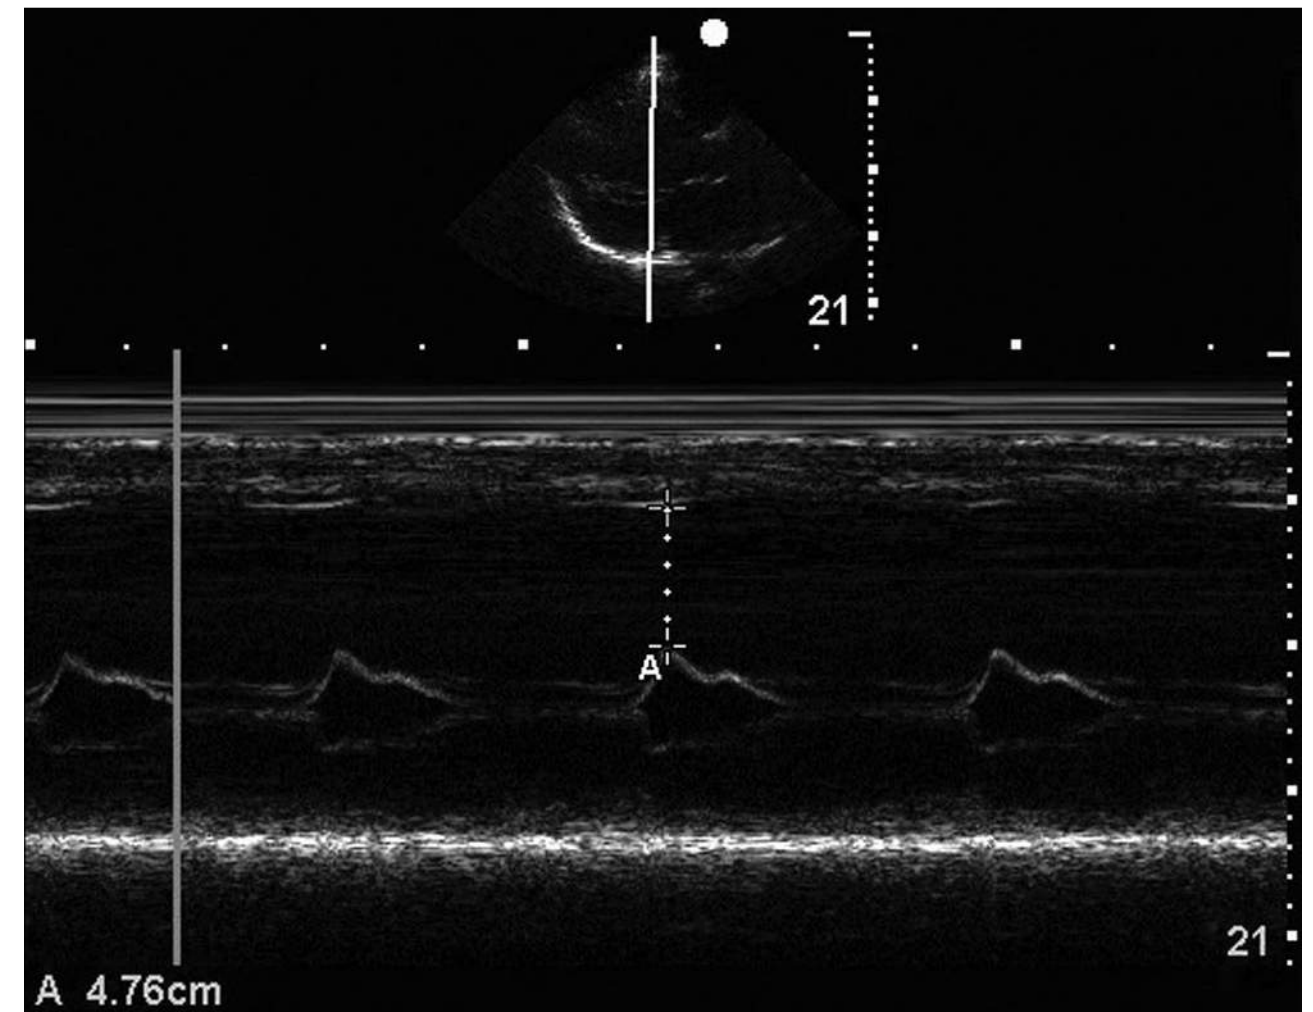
Parasternal long-axis M-mode view, poor ejection fraction, abnormal E-point septal separation (EPSS). Parasternal long-axis M-mode view with M-mode with marker across the anterior mitral valve (MV) leaflet, with the movement of the anterior MV leaflet plotted versus time. Note the markedly increased EPSS. This is most commonly secondary to reduced left ventricular function, but can also be seen in mitral stenosis and aortic regurgitation.
